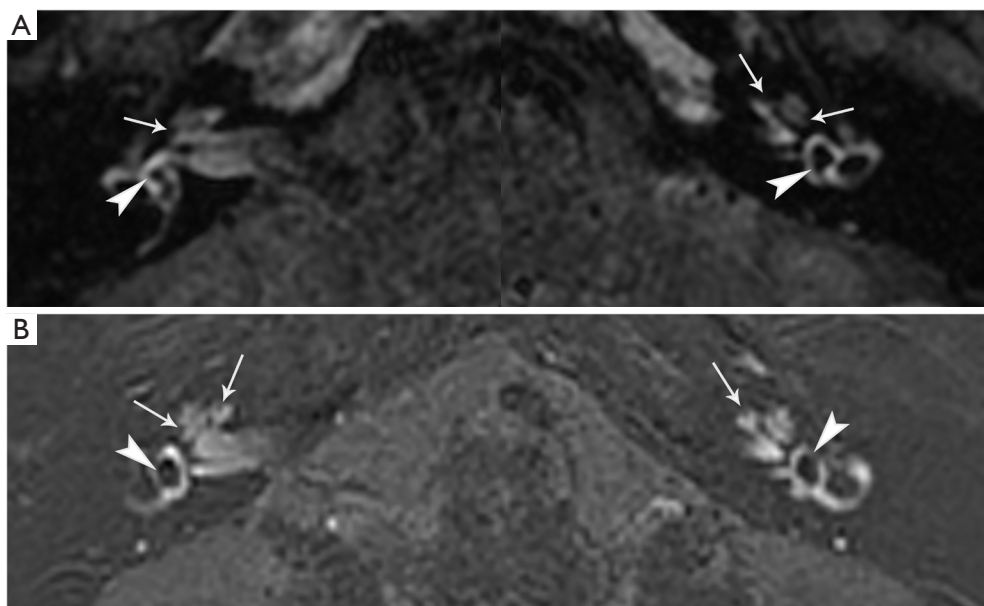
A 3D-FLAIR (A) and 3D-real IR (B) MRI of a 71-year-old man with definite unilateral left-sided Ménière's disease at the first and second hospitalization, respectively. There is no apparent change in the degree of cochlear hydrops (arrows) in the bilateral inner ear or vestibular hydrops (arrowhead) in the left inner ear, whereas the degree of vestibular hydrops (arrowhead) in the right inner ear progressed. MRI, magnetic resonance imaging.
